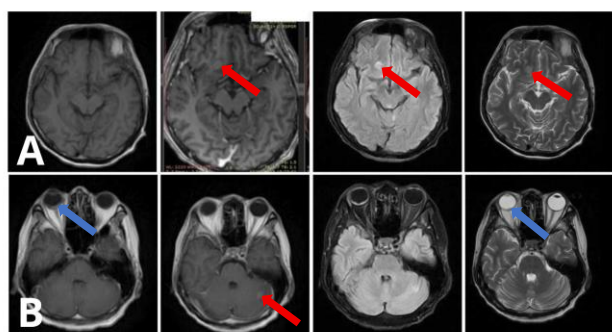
Contrast-enhanced brain MRI (A) and orbital MRI (B) images. Axial MRI demonstrating multiple metastatic lesions. Red arrows indicate intra-axial brain metastases, while the blue arrow points to a solid intraocular lesion in the posterior right retina consistent with retinal/choroidal metastasis. Minimal perilesional edema is noted
